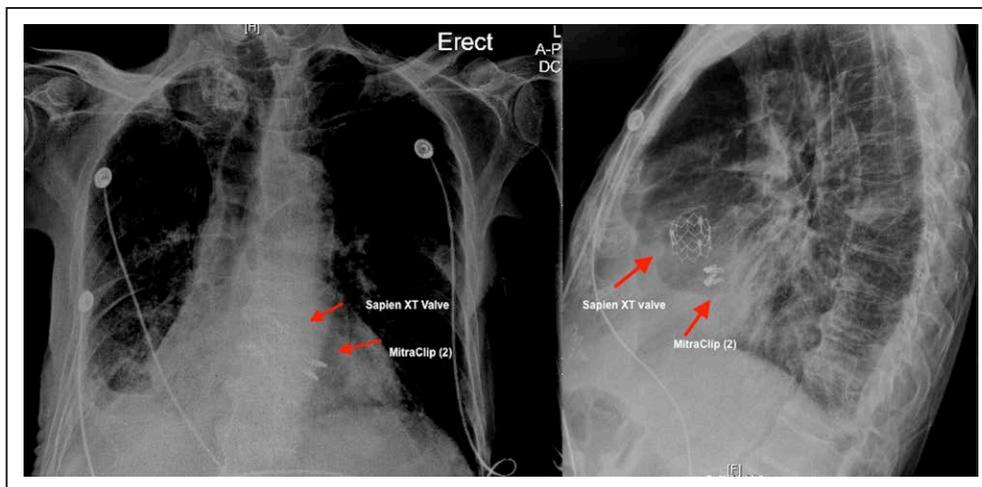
Chest x-ray post-MitraClip and transcatheter aortic valve replacement.
